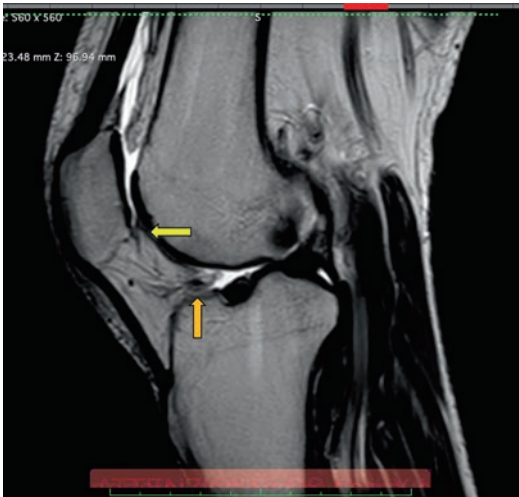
MRI showing a fibrotic infrapatellar plica (yellow arrow) and anterior synovial hypertrophy (orange arrow)
